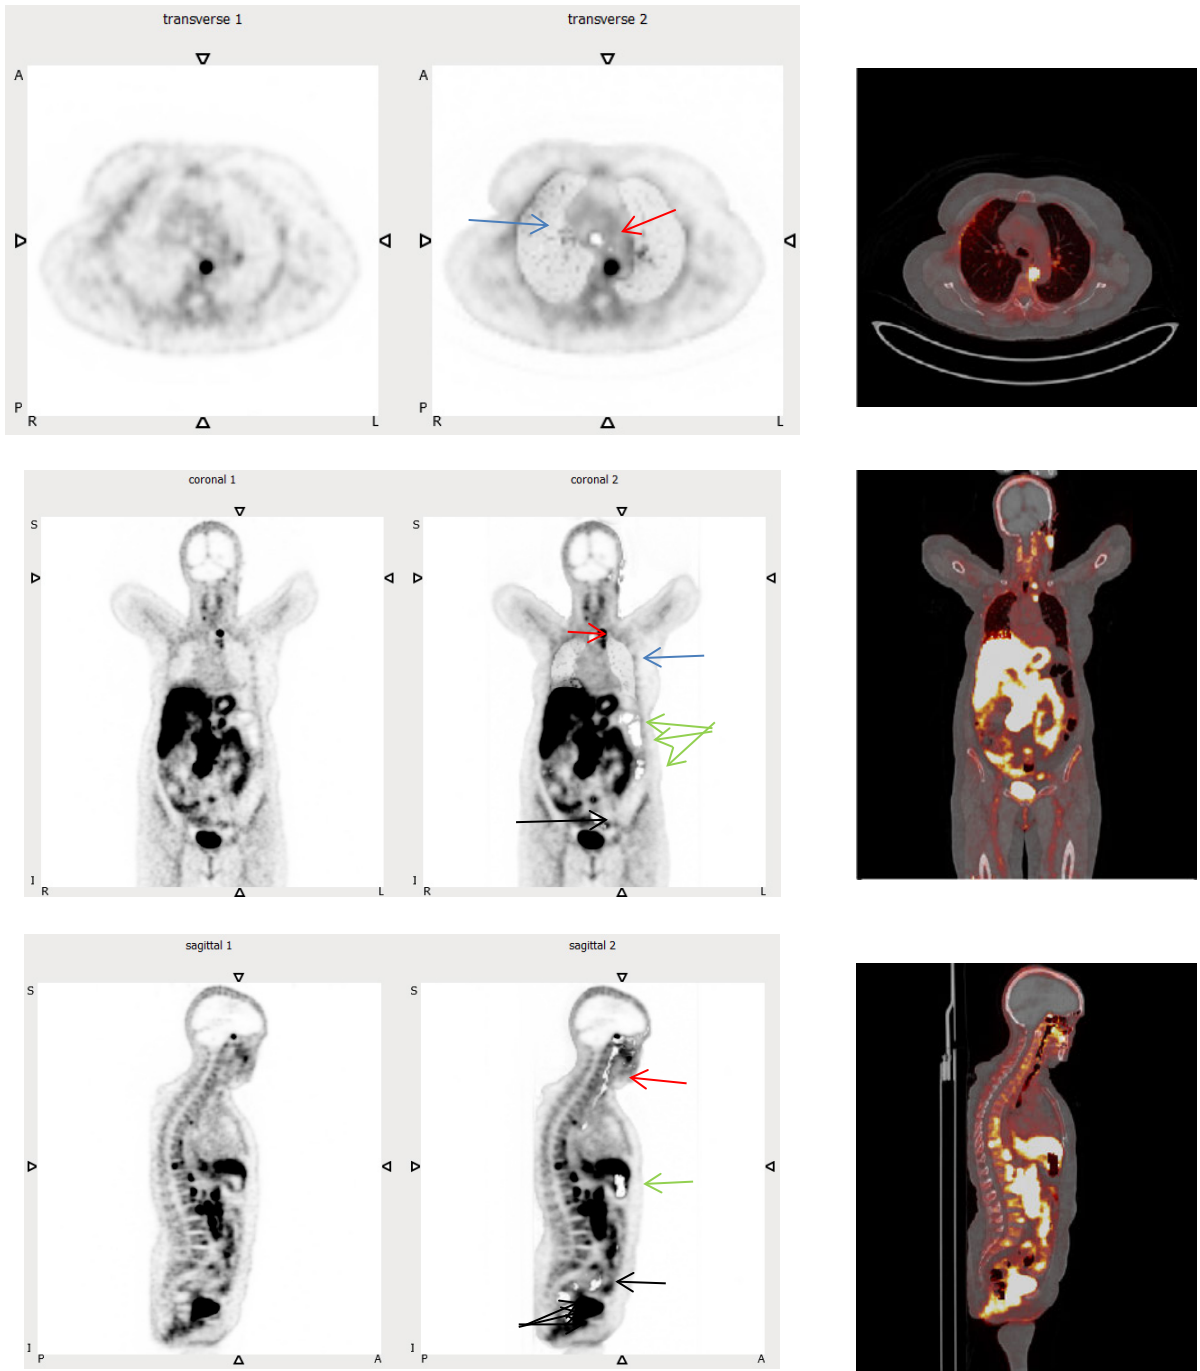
The first row is transverse, the second row is coronal and the third row is sagittal views of patient 04. The first column from the left is the PET<sub>0</sub> image, the second column is the PET<sub>1</sub> image and the third column is the PET<sub>1</sub>/CT fused image. Red arrows indicate the trachea, blue arrows indicate the lung, green arrows indicate the air region in the abdominal area and black arrows indicate the air region in the pelvis area. The PET<sub>1</sub>/CT image demonstrated that both images were aligned and the air regions were matched.
